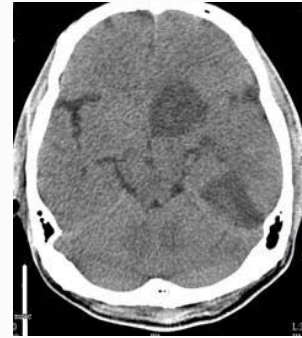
CT shows left brain infarction.
